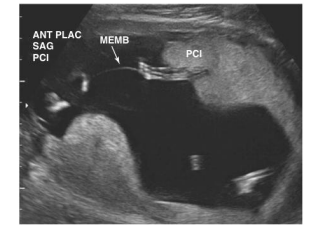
Ultrasound of a twin-twin transfusion syndrome with one twin (upper left) in an amniotic cavity with a reduced fluid volume and a membrane separating this fetus from the second twin in an amniotic cavity with an excessive amount of fluid (right and lower half of scan image). ANT PLAC, Anterior placenta; MEMB, membrane (amion); PCI, placental cord insertion; SAC, sagittal view.
